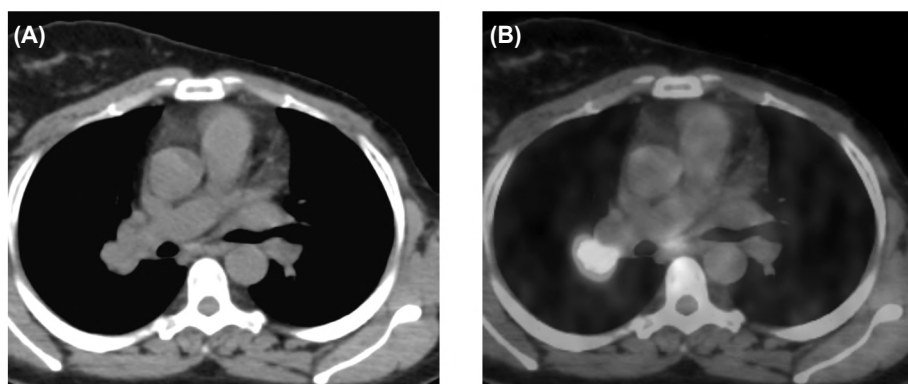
PET-CT revealed glucose avid right para-hilar and mediastinal nodal lesion.
